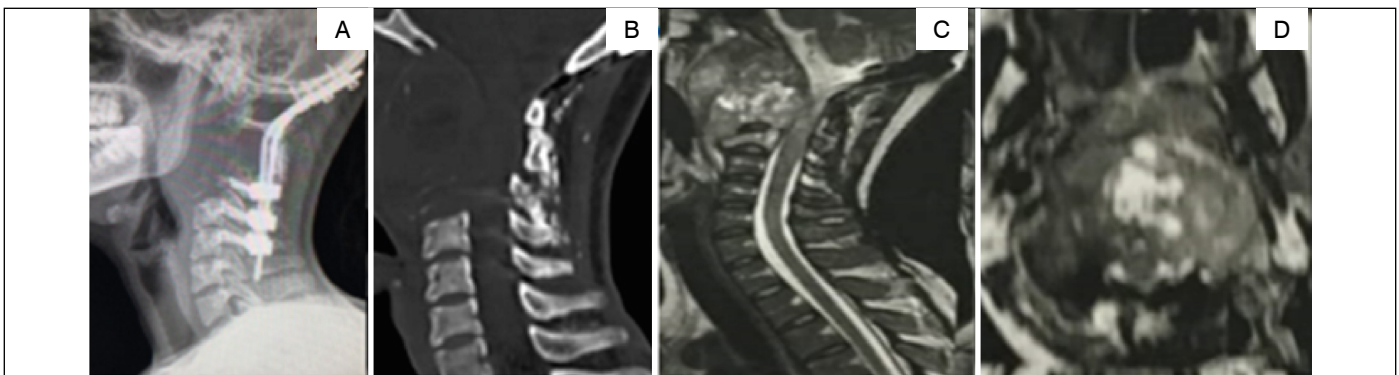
(case 4): A and B – X ray and CT scan showing lytic lesion from C0-C4. C and D – T2 MRI sagittal and axial views showing heterogeneous lesion in CVJ.
